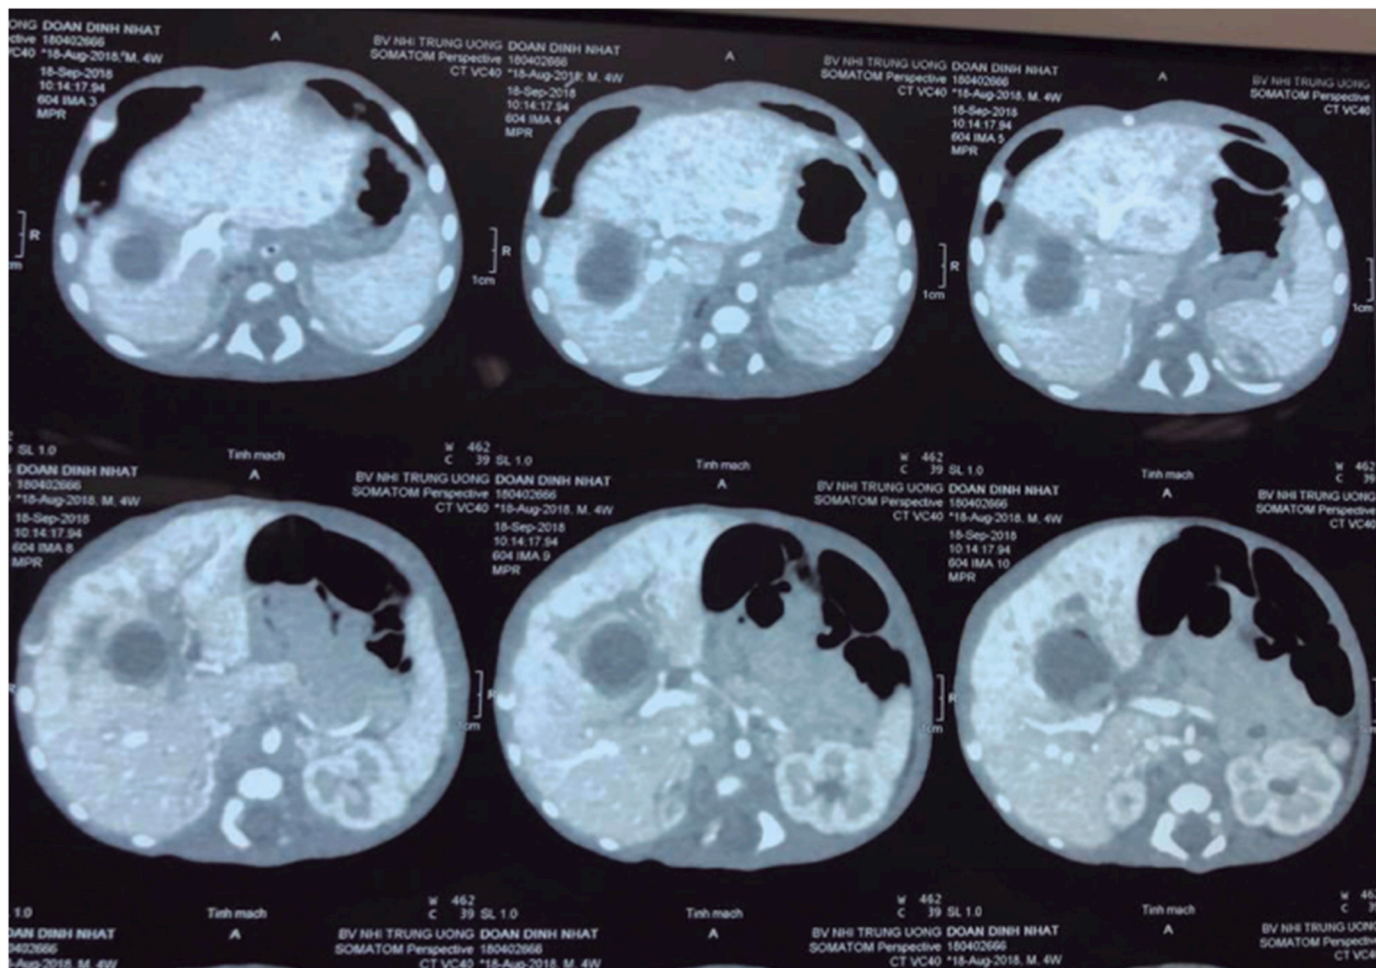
Liver abscess on abdominal CT scan in Case 1.
